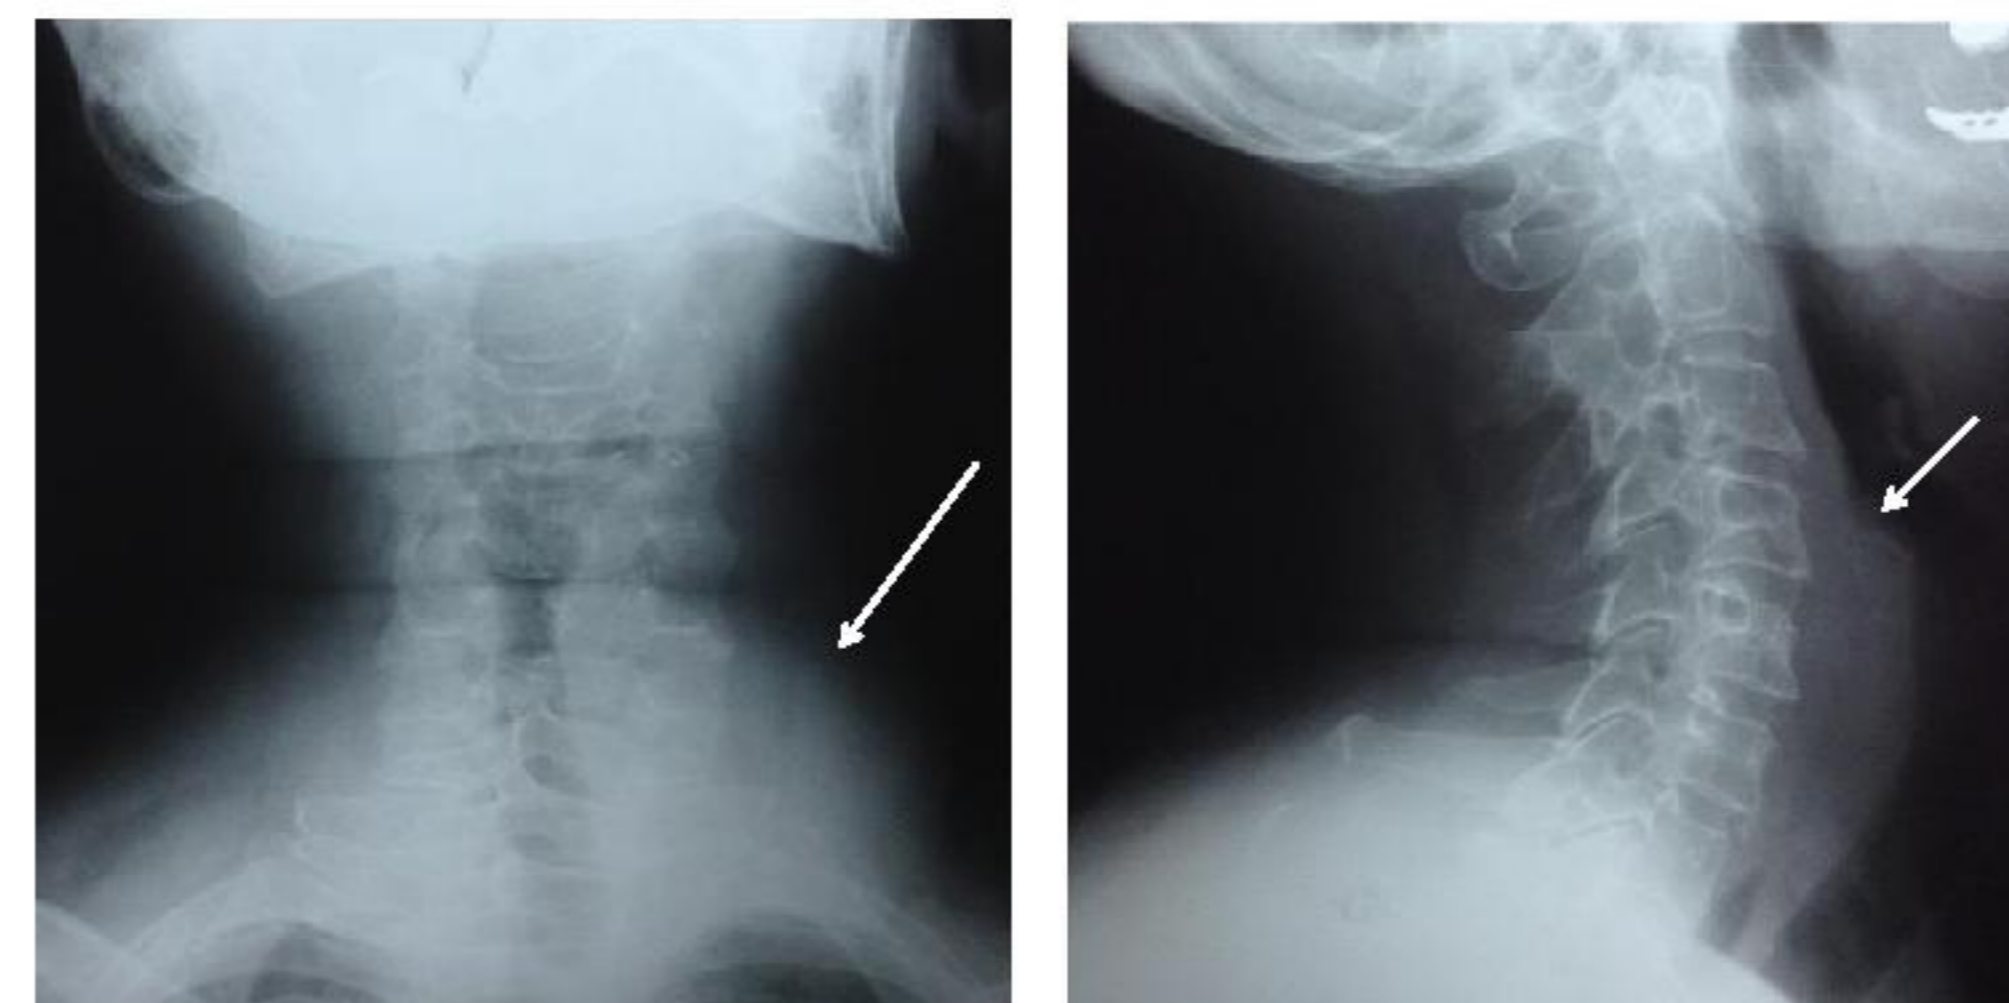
Face and lateral cervical X-Ray
